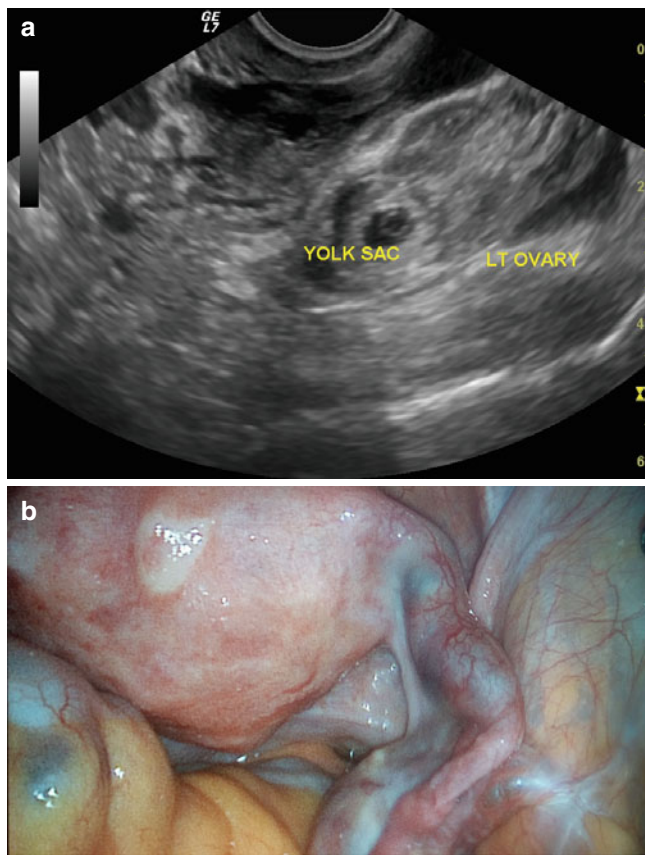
(a) An ultrasonographic image showing a left heterotopic tubal pregnancy and (b) a laparoscopic image of a right tubal pregnancy
